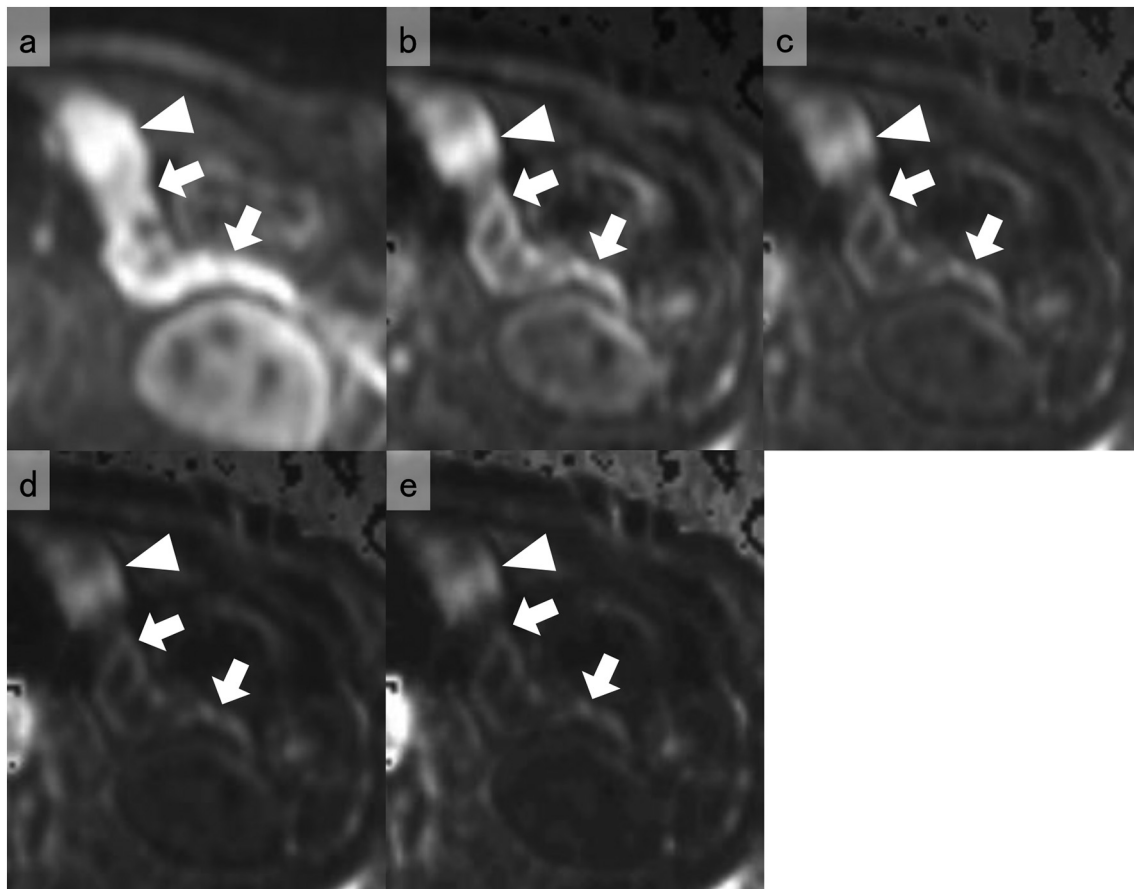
Diffusion-weighted and computed diffusion-weighted images of pancreatic cancer (arrowheads) and tumor-associated pancreatitis (arrows) in a 65-year-old female patient. Scores for tumor conspicuity/total image quality on (a) DWI₁₀₀₀, (b) cDWI₁₅₀₀, (c) cDWI₂₀₀₀, (d) cDWI₂₅₀₀, and (e) cDWI₃₀₀₀ were 2/4, 3/3, 4/2, 4/2, and 4/1, respectively. DWI, diffusion-weighted imaging; cDWI, computed diffusion-weighted imaging.
